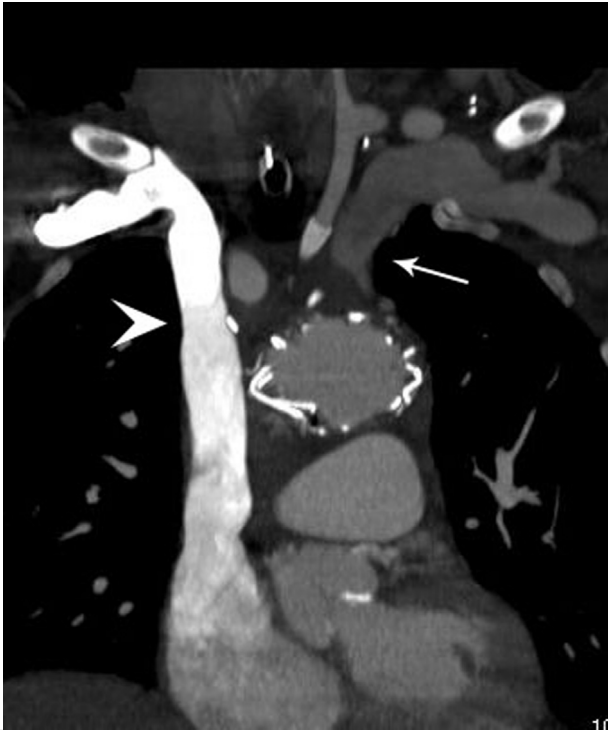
Computed tomography angiography reconstruction, demonstrating complete obstruction of the left brachiocephalic vein (arrow). Note patent right brachiocephalic vein and SVC (arrowhead).
